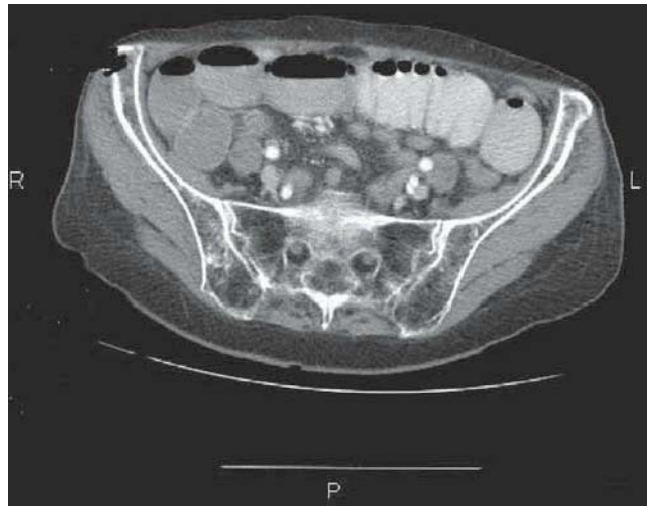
Axial CT demonstrating multiple dilated loops of small bowel compatible with a small bowel obstruction. Figures 10.14 and 10.15 are images corresponding to the same case.
